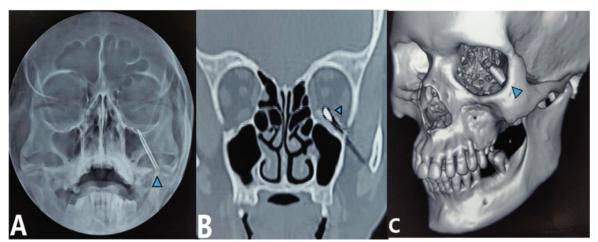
(A) X-ray, (B) CT scan and (C) CT face with 3D reconstruction, showing the intra-orbital foreign body (highlighted by arrowhead)
